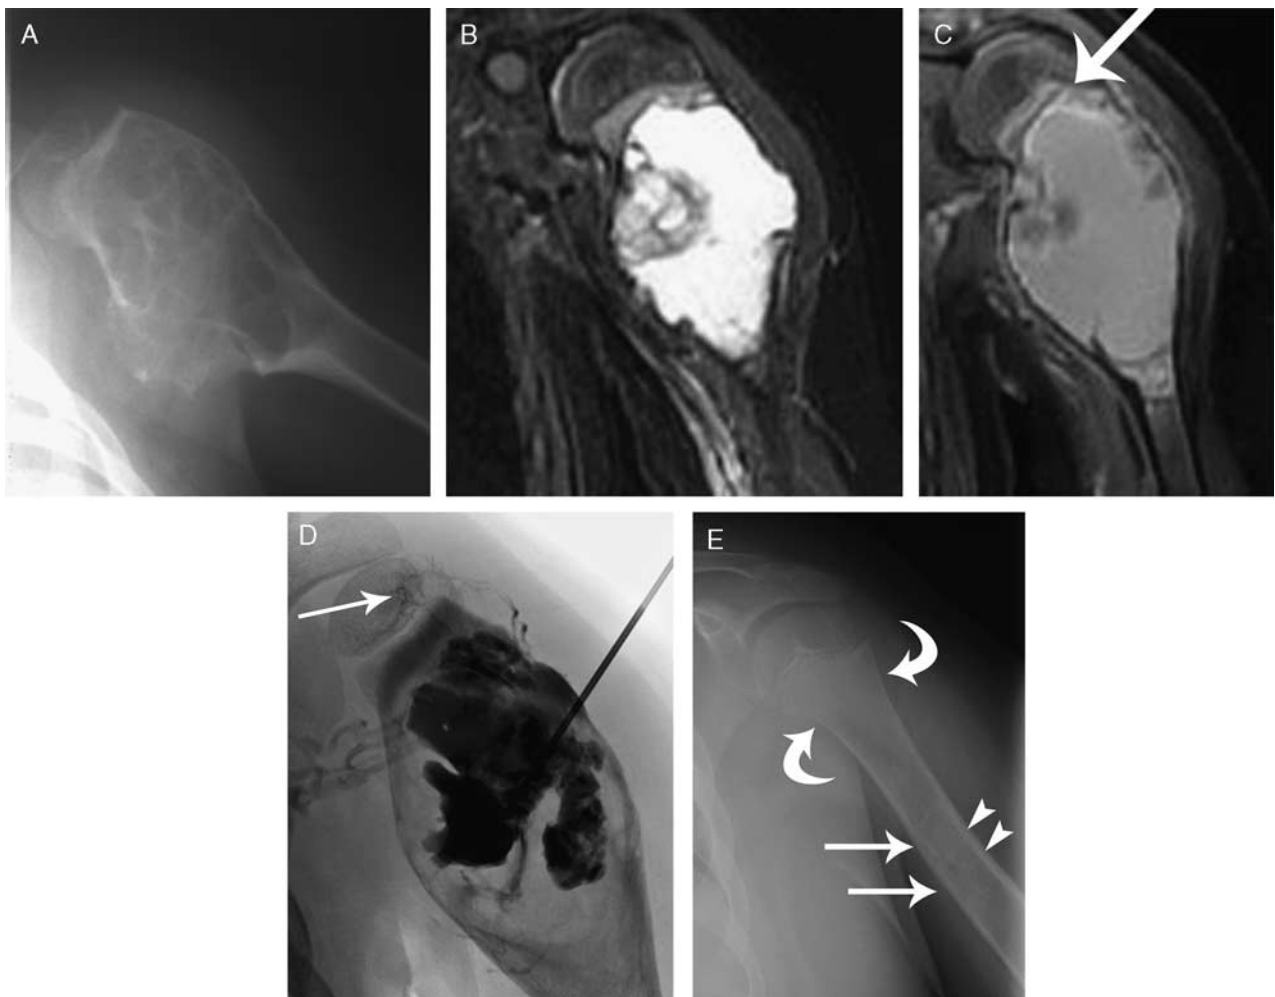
A 4-year-old male with left proximal humeral ABC with physeal involvement before treatment. A, Radiograph of the left humerus before percutaneous doxycycline treatment demonstrating lytic, expansile metaphyseal changes from the ABC. B, T2-weighted MRI demonstrates the extensive metaphyseal involvement of the multilocular ABC. C, Gadolinium-enhanced T1-weighted MRI demonstrates physeal, but no transphyseal involvement of the ABC (arrow). D, Fluoroscopically guided contrast injection before doxycycline injection demonstrates contrast filling the ABC cystic locules as well as normal transphyseal vascular channels (arrow). E, Radiograph of the left humerus 67 months following treatment demonstrates healing of the lytic destructive ABC foci (arrows) and cortical thickening in the healed ABC site (arrowheads), remodeling of the proximal humerus metaphysis with a concave metaphyseal waist (curved arrows), and distal migration of the healed ABC bony scar into the proximal humerus diaphysis (arrows), and no radiographic evidence of physeal growth disturbance or physeal bony bridge. ABC indicates aneurysmal bone cyst; MRI, magnetic resonance imaging.
